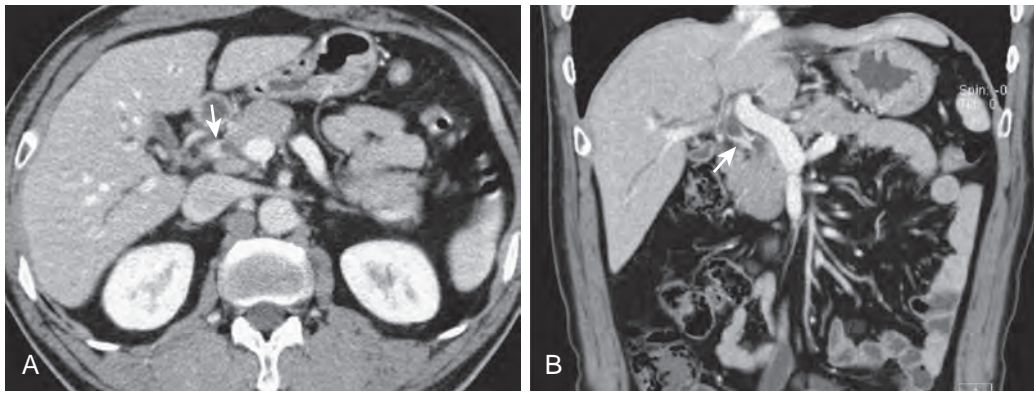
Extrahepatic cholangiocarcinoma. A. Axial CT during the portal venous phase shows an enhancing mass (arrow) in common bile duct. B. Coronal multiplanar reconstructed (MPR) image demonstrates focal mural thickening and enhancement (arrow) of common bile duct.
